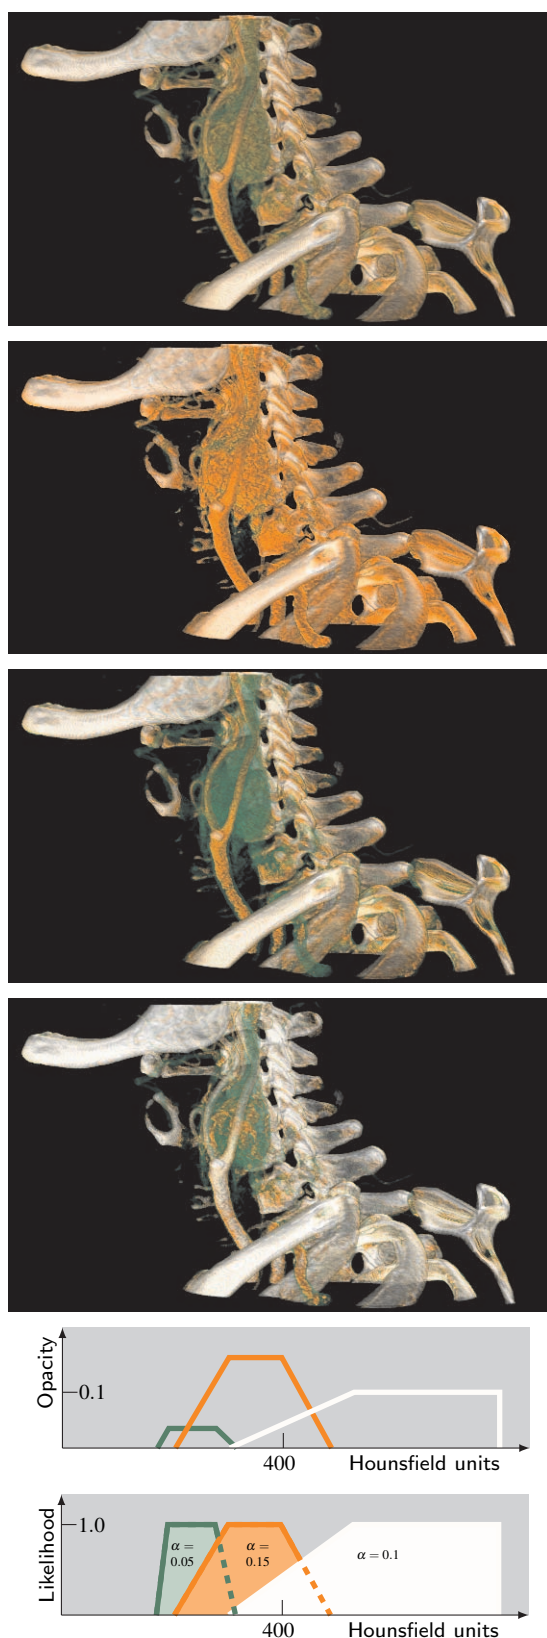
CT examination of thyroid tumor. The top image is a traditional diagnostic visualization with overlapping TF components for tumor (green), vessels (orange), and bone (white). The following three images are different frames from an uncertainty animation in material sync mode. The dramatic differences show that there is much inherent uncertainty in the traditional rendering to be explored. The traditional and probabilistic TFs are given, the latter at the bottom.
